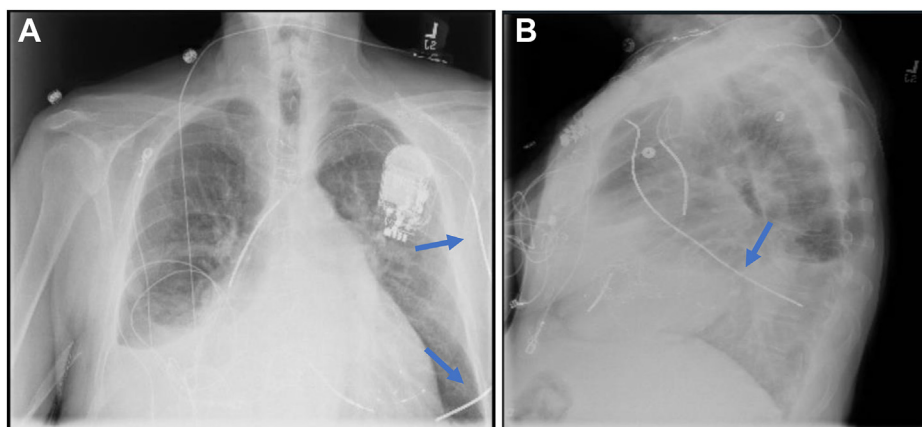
A, B: Chest radiograph after introducing the subcutaneous array (blue arrow).
